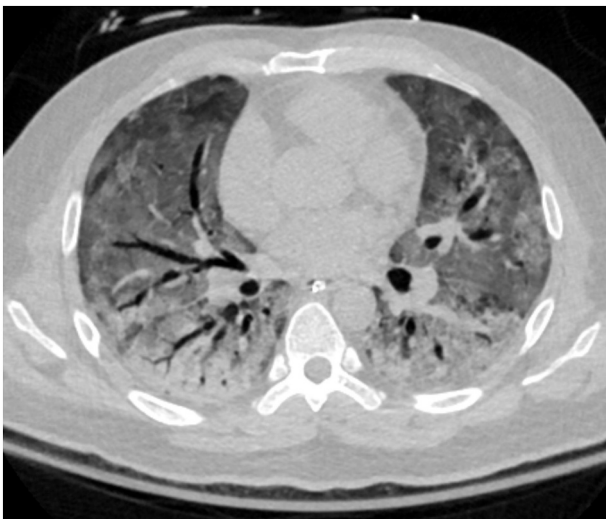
Axial CT angiography of the chest in lung window. Diffuse bilateral ground glass pulmonary opacities with dependent consolidation and dilated airways, suggestive of diffuse alveolar damage.
